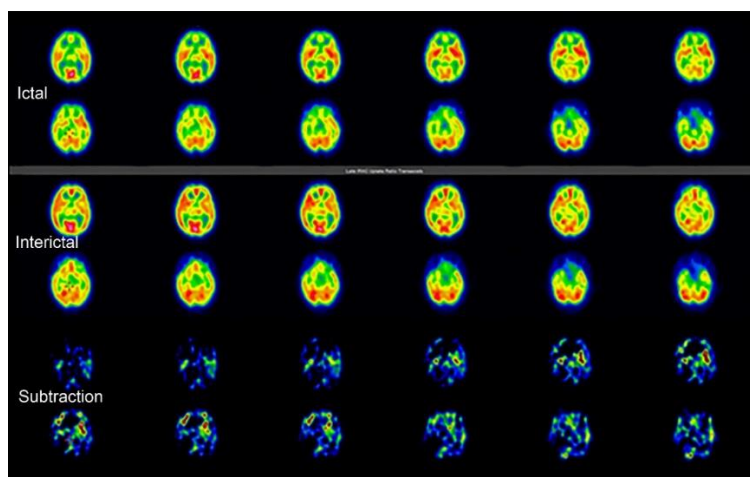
Example of ictal SPECT (two top rows), interictal SPECT (two middle rows), and ictal-interictal subtraction SPECT images (two bottom rows) in the same case using Q.Brain software to identify the maximum difference of radioactivity count statistics between both SPECT image
